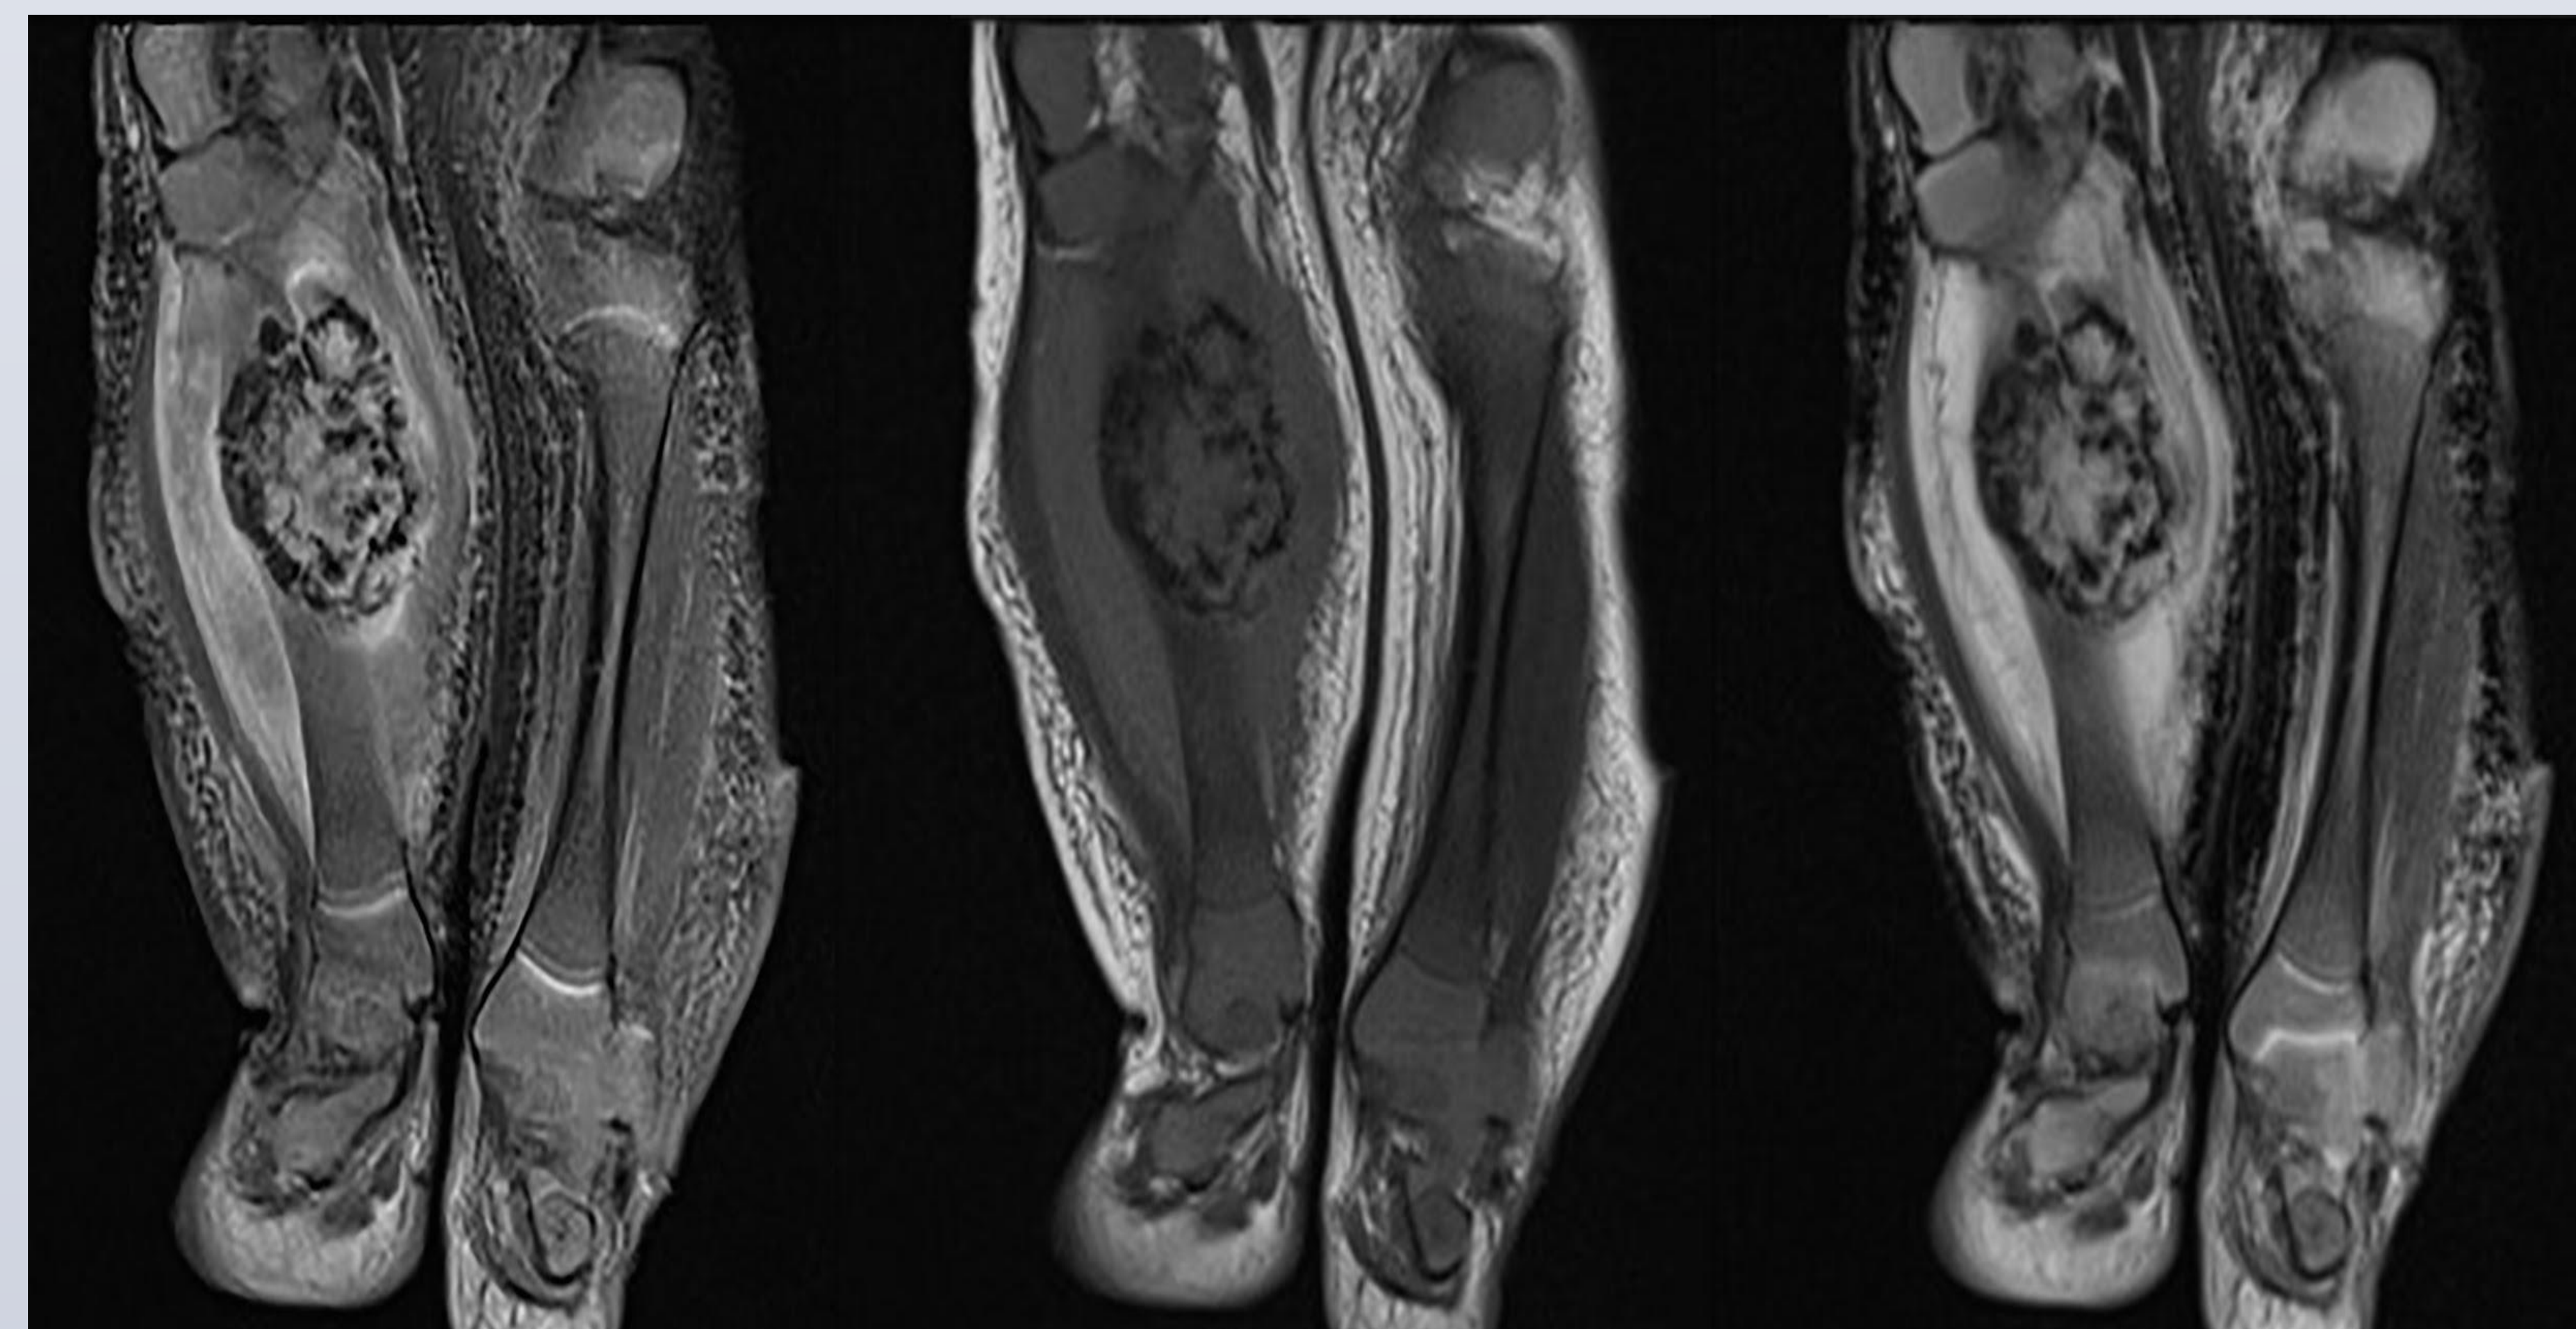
T2, T1, and T2 fat saturated coronal magnetic resonance images of the right tibia and fibula demonstrating an aggressive mass composed of chondroid matrix with surrounding periosteal reaction and increased fluid signal about the mass
